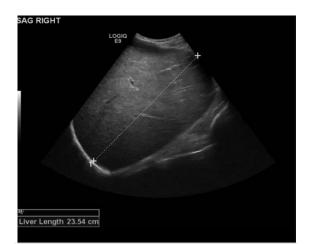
Ultrasound image shows hepatomegaly(23.54 cm) in patient 19 yrs with SCA (www.event scribe.com).
